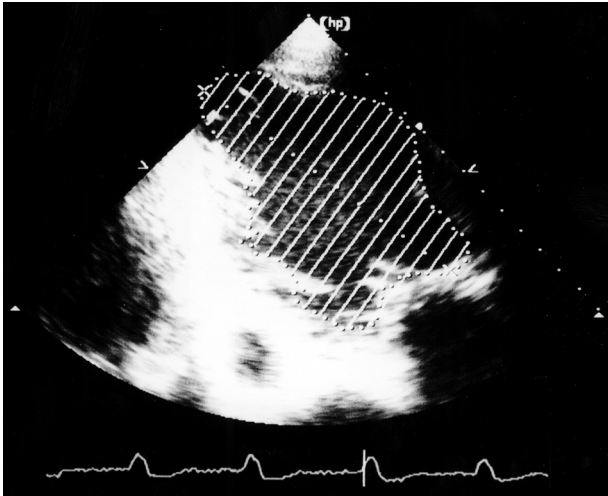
Preoperative echocardiography showed left ventricular end diastolic volume index of 167 ml.
